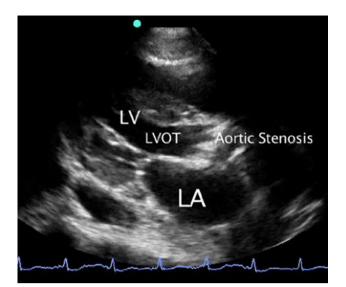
Critical aortic stenosis parasternal long-axis view
